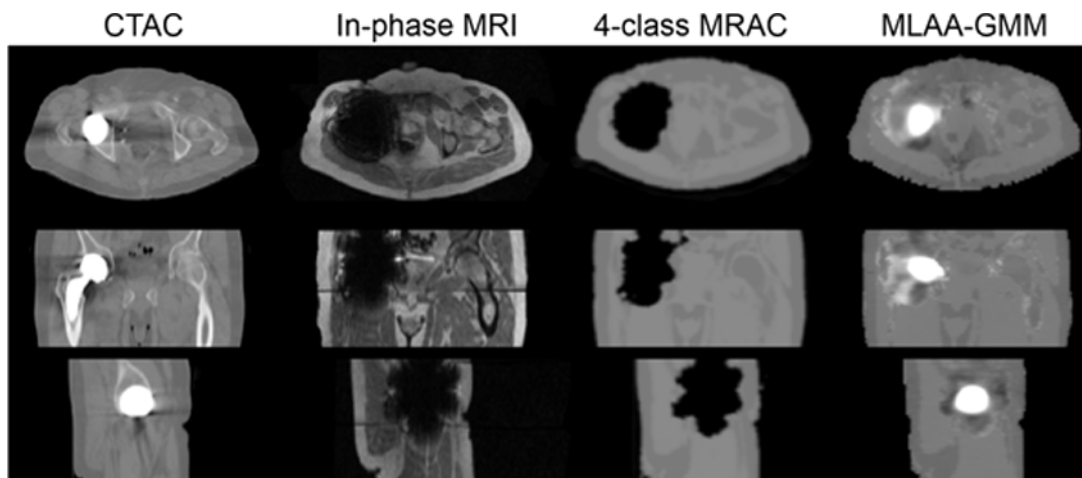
The compensation of metal induced susceptibility artifacts in MRAC maps using the MRI-guided MLAA algorithm described in Ref. 87.
